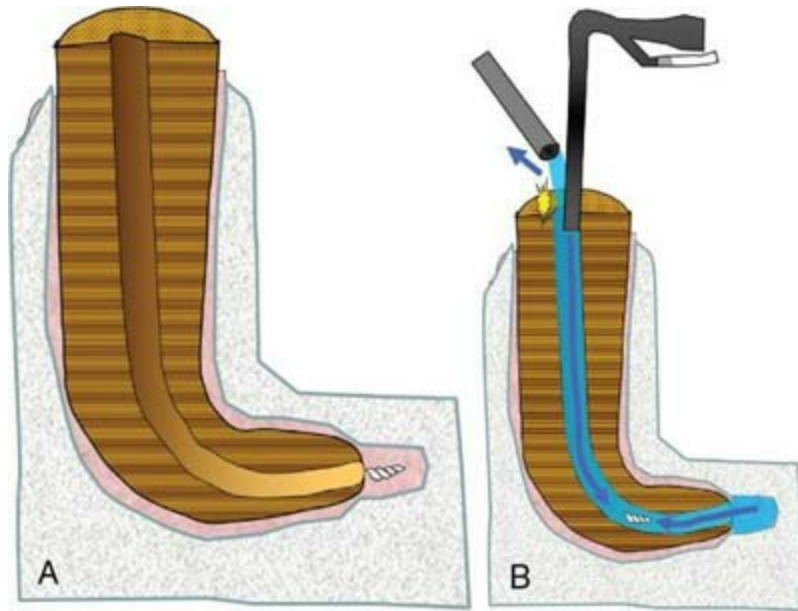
A, Separated file loose beyond the radicular foramen. B, Ultrasonic irrigation such as ProUltra PiezoFlow using saline may help retrieve the separated file which is not engaged in the canal wall.
